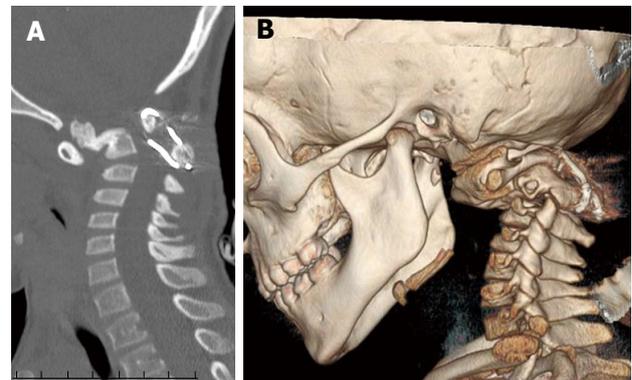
Five months post-operative follow-up. Sagittal thin slice CT image (A) and volume rendering CT image (B): Consolidation of C2 fracture with moderate stenosis of the occipital hing.
